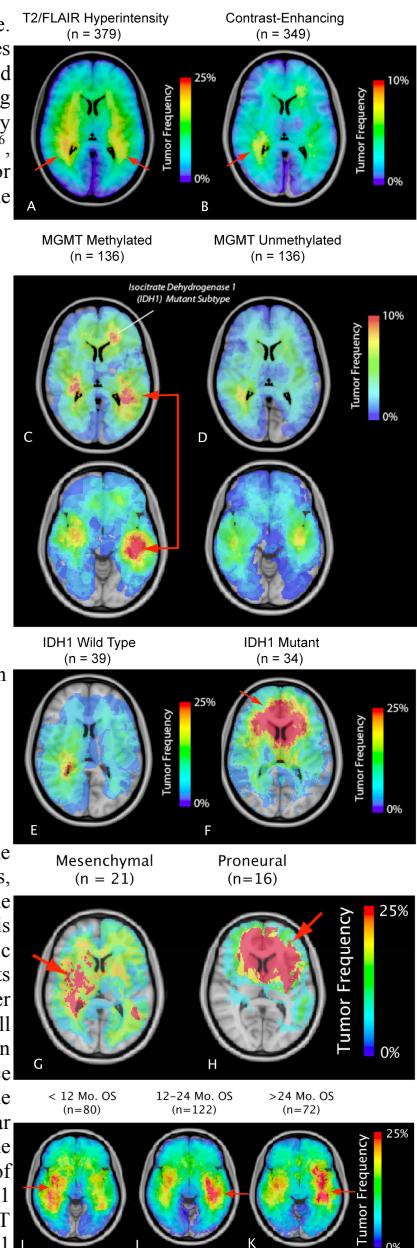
Probabilistic Atlases for Common Glioma Phenotypes A) T2/FLAIR hyperintense lesions in GBM. B) Contrast-enhancing lesions in GBM. C) MGMT promoter methylated GBMs. D) MGMT promoter unmethylated GBMs. E) IDH1 wild type tumors in gliomas (WHO II-IV). F) IDH1 mutant tumors in gliomas (WHO II-IV). G) “Mesenchymal” gene expression subtype in GBM. H) “Proneural” gene expression subtype in GBM. I) OS < 12 mo. J) OS 12-24 mo. K) OS > 24 mo.
